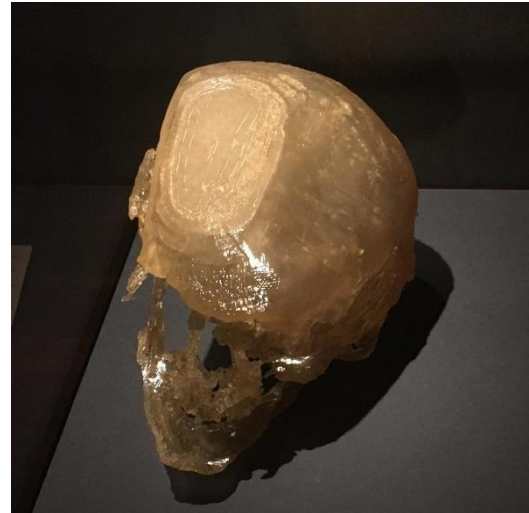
Grauballe Man's skull replicated from CT scans, Mosegaard Museum (Photograph, M. Schlanker 2018)
